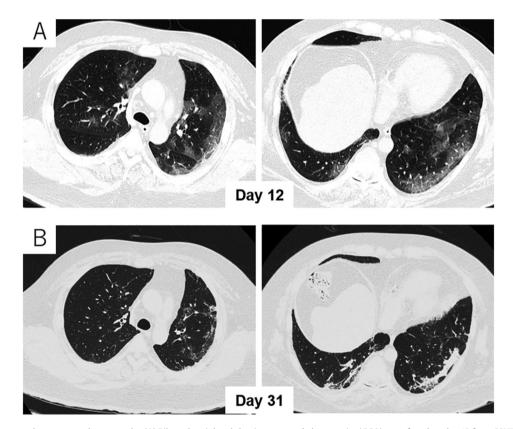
Abnormal shadows on chest computed tomography. (A) Bilateral peripheral-dominant ground glass opacity (GGO) were found on day 12 from COVID-19 diagnosis. (B) GGO in the upper regions of lungs were resolved, whereas GGO in the lower regions of lungs was partially resolved and the remaining was converted to consolidation.
